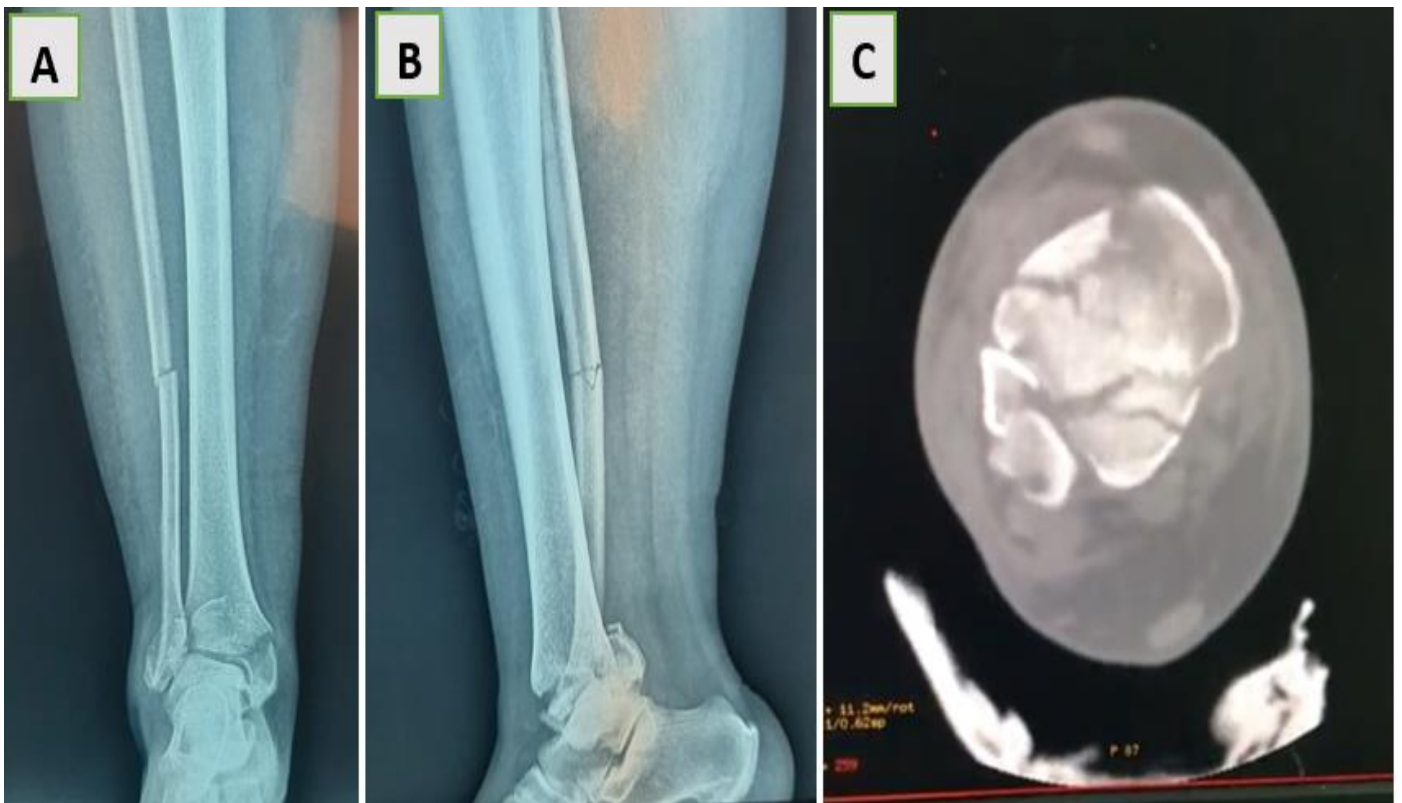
Initial radiograph (A, B) of a comminuted fracture involving the epiphyseal region of the tibial pilon with a CT image (C) in axial section objectifying the degree of epiphyseal comminution.
